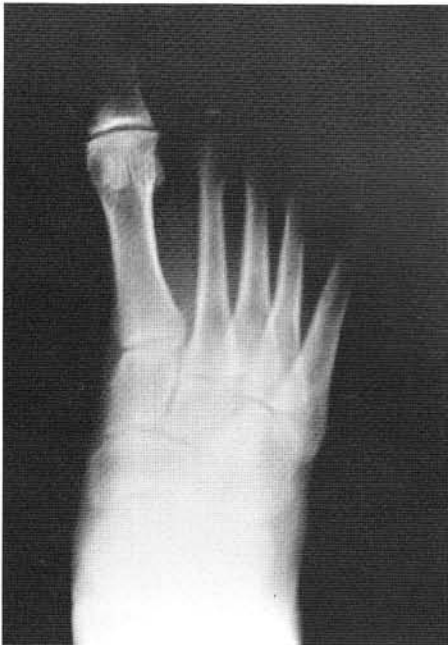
Preoperative DP weight-bearing radiograph with hallux limitus.
